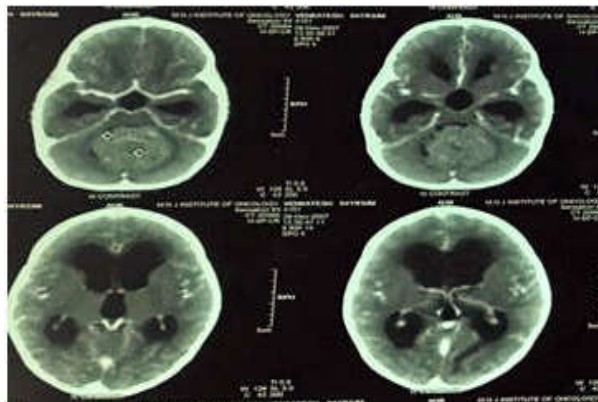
A contrast CT brain showing obstructive hydrocephalus
